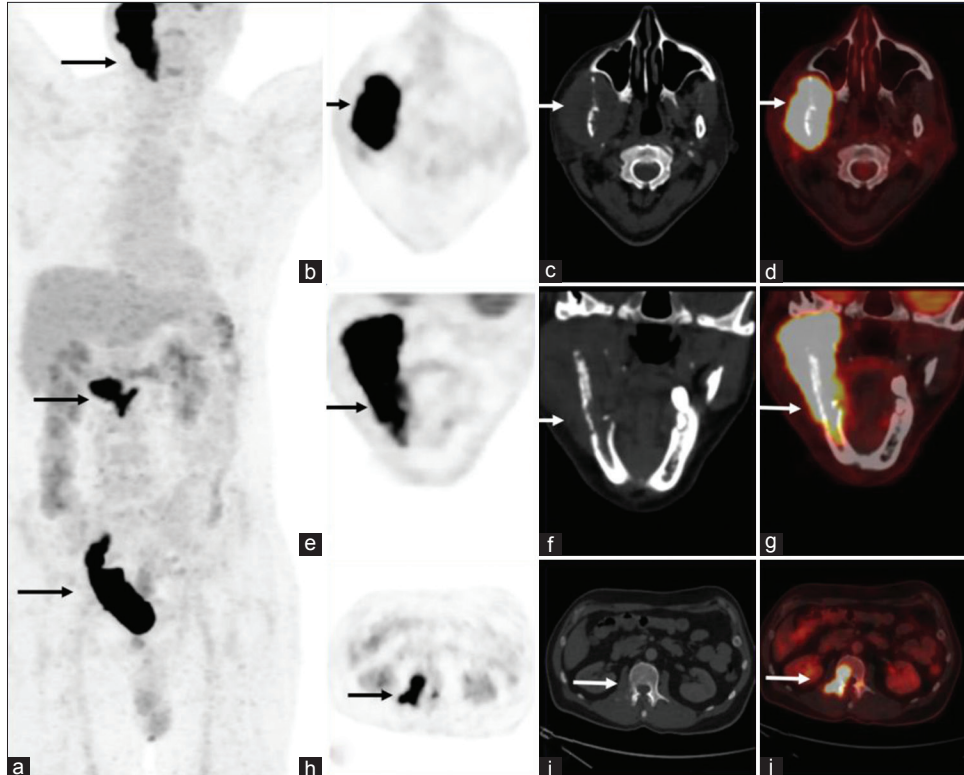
MIP (a) image of postoperative carcinoma urinary bladder patient showing FDG avid lesion in the right mandibular region, lumbar vertebrae, and ileal conduit. Axial and coronal (b-g) PET, CT, and fused PET-CT images showing FDG avid osteolytic destructive lesion involving ramus and condyle of the right mandible and FDG avid osteolytic lesion in L2 vertebra in axial (h-j) PET, CT, and fused PET-CT images
